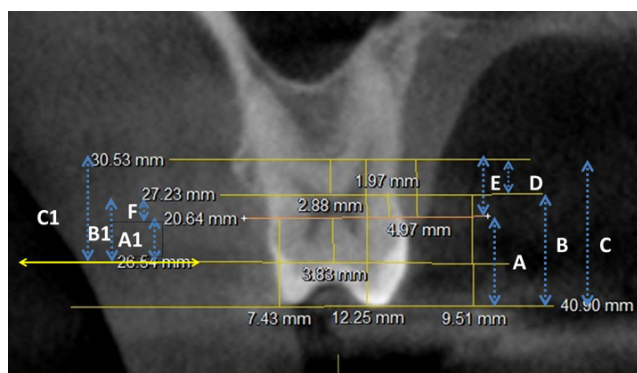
CBCT image of the maxillary molar showing the nine measurements (A, B, C, D, E, F, A1, B1, C1) taken in this study.
